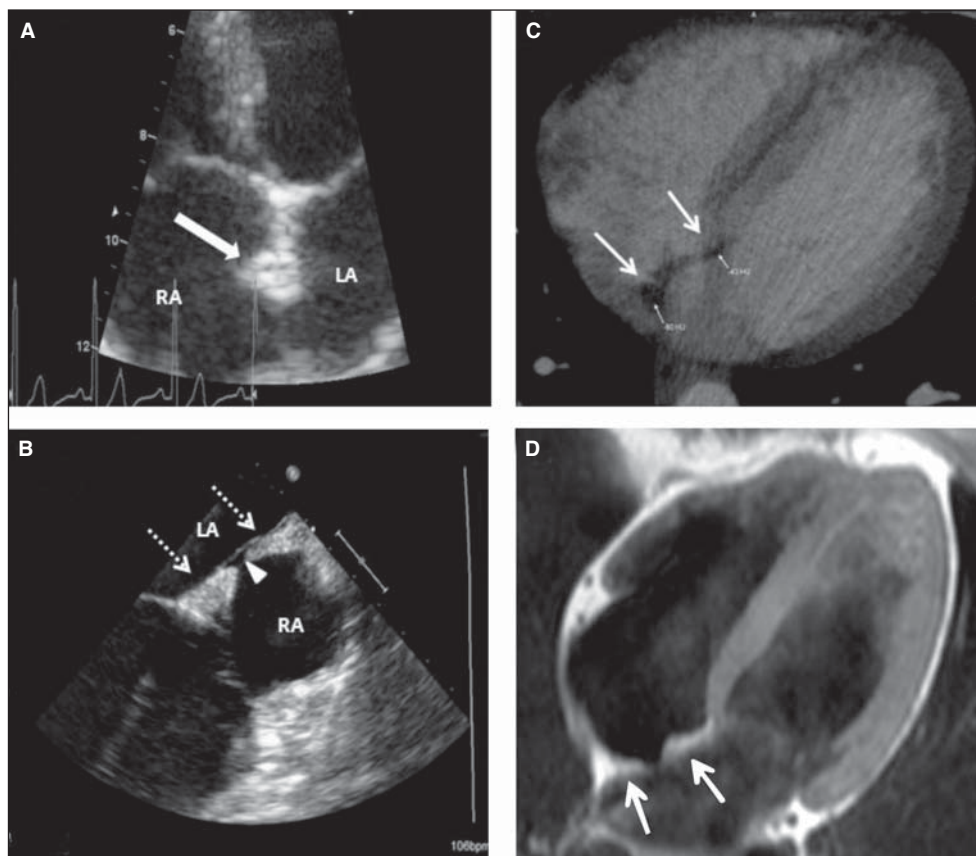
A: Transthoracic apical four-chamber view showed a hyperechogenic mass (thick arrow) in the interatrial septum. B: Transesophageal echocardiography at the mid-oesophageal 180° level showing thick and hyperechogenic interatrial septum (dotted arrows) with not spread to the foramen ovale (arrowhead) suggesting LHIS. C: Presence of LHIS (thin arrows) without typical sparing of the fossa ovalis with low radiodensity similar to that of subcutaneous fat. D: Cardiac magnetic resonance image shows the characteristic a homogenous bilobed, non-encapsulated high signal density mass in the superior and inferior limbus of the interatrial septum which appears brighter than myocardium and similar to epicardial fat (white arrows) (RA: Right atrium, LA: Left atrium).
